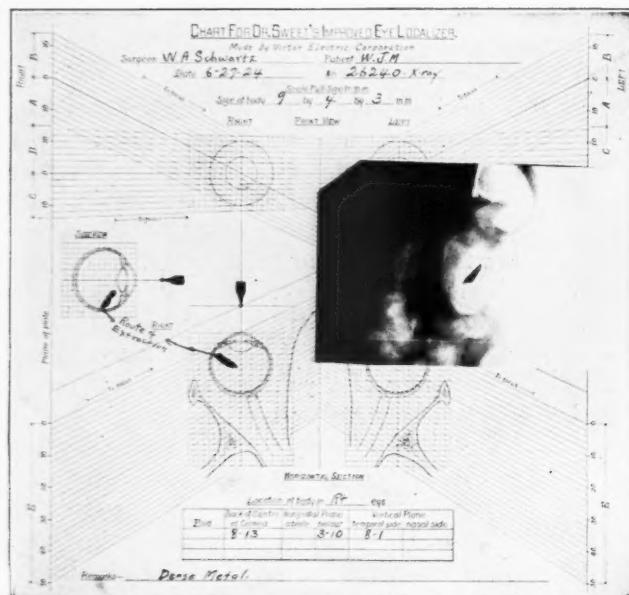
W. J. M., injured June 22, 1924. Examination of right eye on June 26 showed perforating wound of sclera on nasal side about  $1\frac{1}{2}$  mm. from limbus. Anterior chamber normal; lens slightly cloudy; hemorrhage into vitreous; fundus not visible; vision—fingers at 4 feet. X-ray showed large foreign body, measuring  $9 \times 2 \times 4$  mm., in vitreous chamber, one extremity close to sclera of temporal side. On June 26 incision was made through sclera, over end of foreign body; it was found to be non-magnetic and was removed with forceps, proving to be a particle of brass. On August 14 patient was discharged; eye was quiet; no changes in cornea or lens; massive opacities in vitreous; upper part of fundus could be indistinctly seen; vision—hand movements at one foot. Comment.—Localization of this fragment, so that scleral incision could be made over one end of it, made possible its removal without further trauma. It is very unusual to remove so large a non-magnetic foreign body from the globe and still preserve any vision, or even to preserve the eye for cosmetic value.
